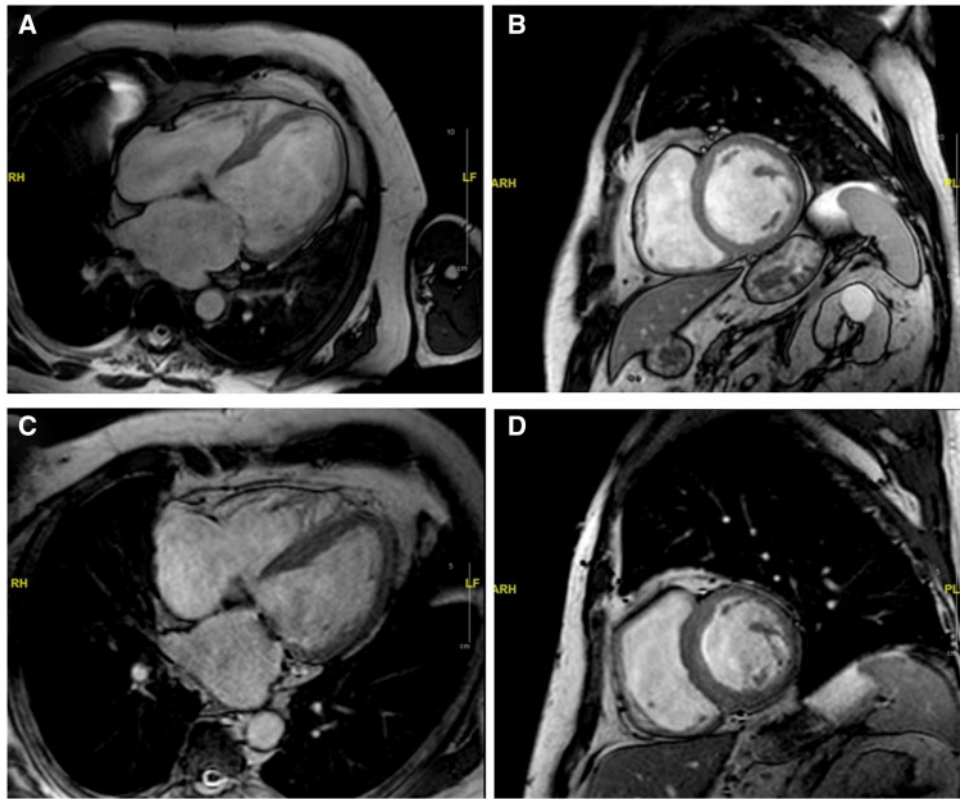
Comparison of pre- and post-operative cardiac magnetic resonance imaging showing remarkable reverse cardiac remodeling. Preoperative (A) and (B): left ventricular ejection fraction 22%; left ventricular end-diastolic volume 247 mL; left ventricular end-systolic volume 192 mL. Twenty-four months of follow-up (C) and (D): left ventricular ejection fraction 41%; left ventricular end-diastolic volume 167 mL; left ventricular end-systolic volume 99 mL.
